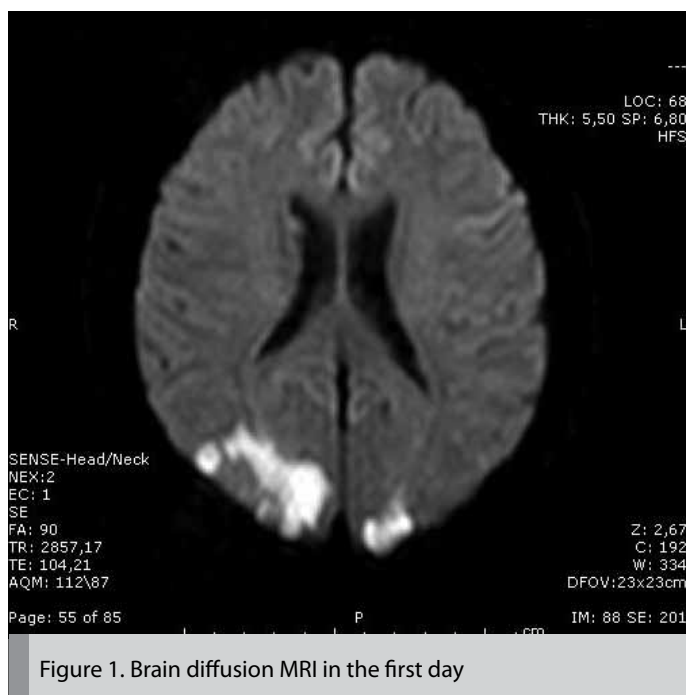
Brain diffusion MRI in the first day
